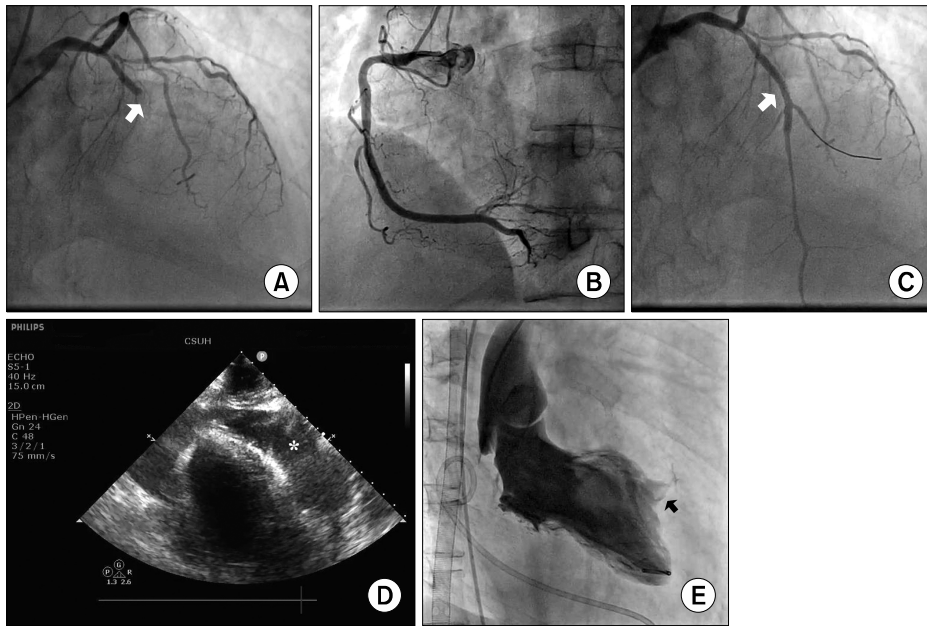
Coronary angiography revealing total occlusion of the proximal left anterior descending coronary artery (LAD) (arrow) (A) and a normal right coronary artery (B). Percutaneous coronary intervention with everolimus-eluting stent implantation (2.75×24 mm, Synergy XD TM, Boston Scientific, Marlborough, MA) in the proximal LAD (arrow) (C). Trans-thoracic echocardiogram showing large amount of pericardial effusion (asterisk) (D). Left ventriculogram showing myocardial rupture in the anterior myocardium (arrow) (E).
